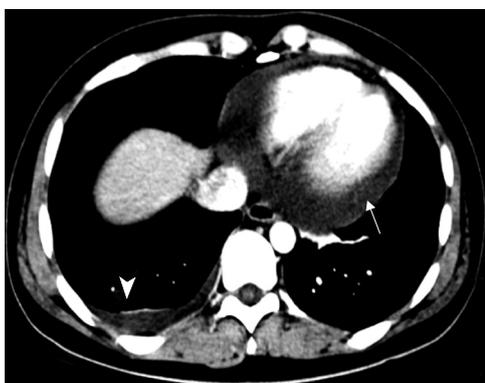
A chest computed tomography (CT) scan showing massive pericardial effusion (arrow) and right pleural effusion (triangle).
